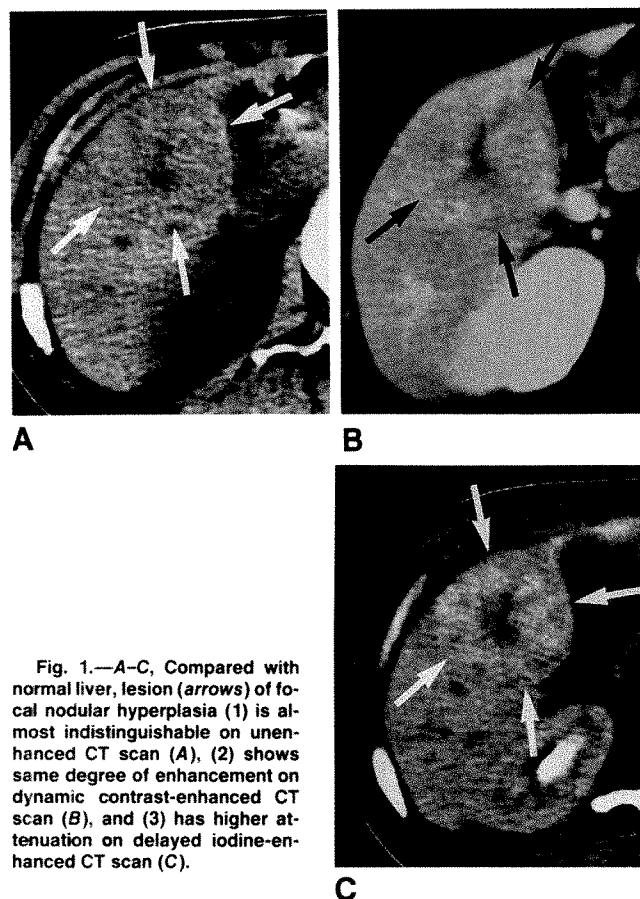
A-C, Compared with normal liver, lesion (arrows) of focal nodular hyperplasia (1) is almost indistinguishable on unenhanced CT scan (A), (2) shows same degree of enhancement on dynamic contrast-enhanced CT scan (B), and (3) has higher attenuation on delayed iodine-enhanced CT scan (C).
